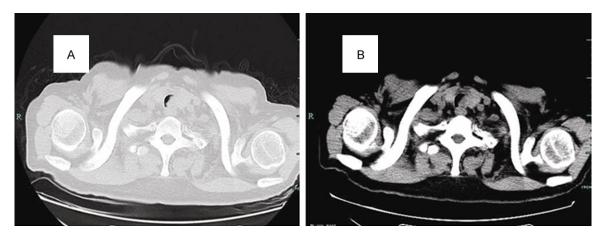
CT revealed a 1.0 cm × 2.5 cm intraluminal, irregular soft tissue mass in the upper trachea, approximately 2.5 cm below the glottis. A. Soft tissue window; B. Bone window.
